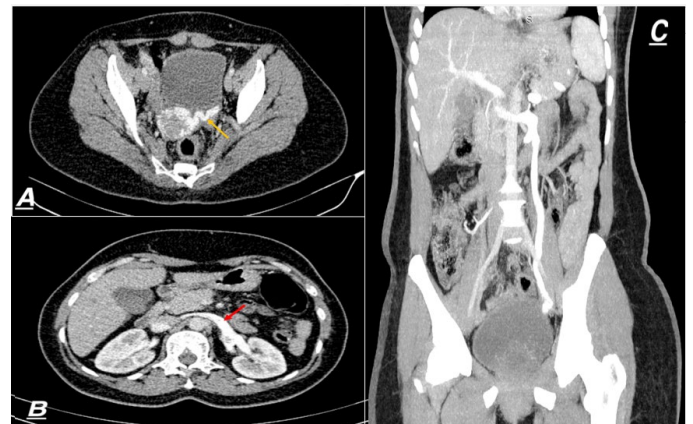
Abdominal-pelvic CT scan in axial and coronal section, in parenchymal windows showing (A) Dilatation of the left ovarian vein (yellow arrow) (B) Dilatation of the left renal vein (red arrow) (C) Distended left ovarian vein draining into the left renal vein.
